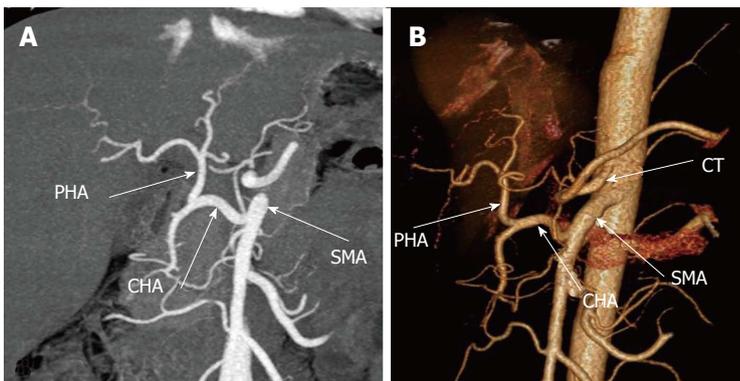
Michel type IX variant is shown in the (A) maximum intensity projection and (B) volume rendered images generated from a computed tomography angiogram. There is a replaced CHA that comes off the SMA. CHA: Common hepatic artery; SMA: Superior mesenteric artery; PHA: Proper hepatic artery; CT: celiac trunk).
